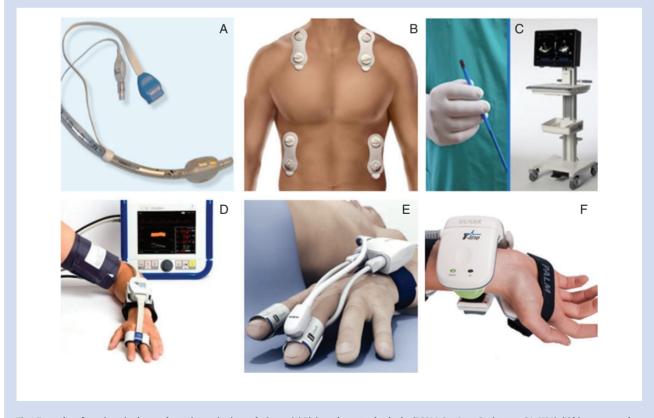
Examples of non-invasive haemodynamic monitoring techniques. (A) Bioimpedance tracheal tube (ECOM, San Juan Capistrano, CA, USA), (B) bioreactance electrodes (Cheetah, Newton Center, MA, USA), (C) miniaturized single-use transoesophageal echocardiography probe (Imacor, Garden City, NY, USA), (D, E) volume clamp finger cuff systems (CNSystems, Graz, Austria and Edwards, Irvine, CA, USA) and (F) applanation tonometry wrist device (Tensys, San Diego, CA, USA). Download English Version:
